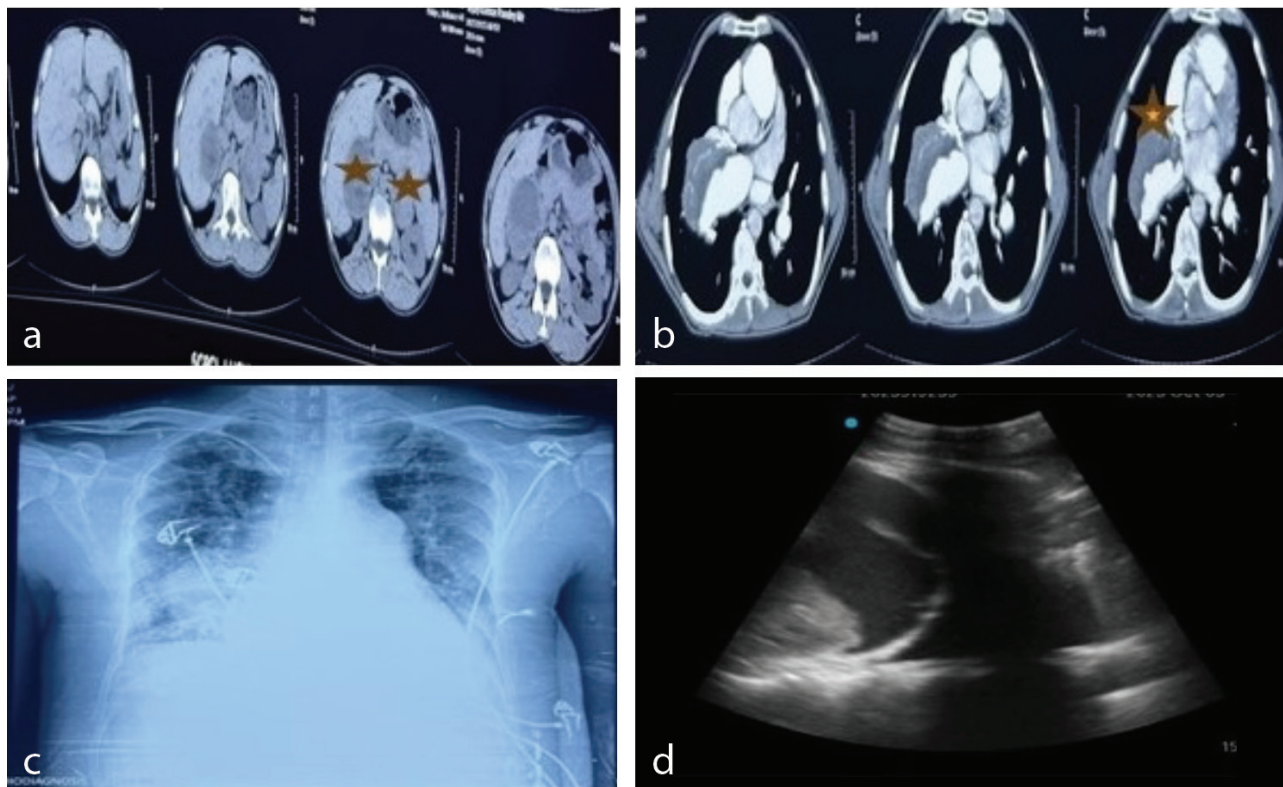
(a) Preoperative CT scan of the abdomen showing bilateral adrenal tumors (see star). (b) Preoperative CT Pulmonary Angio showing thrombus in the right pulmonary artery (see star). (c) Postoperative chest skiagram showing basal atelectasis and blunting of costophrenic angles. (d) POCUS lung showing pleural effusion.
